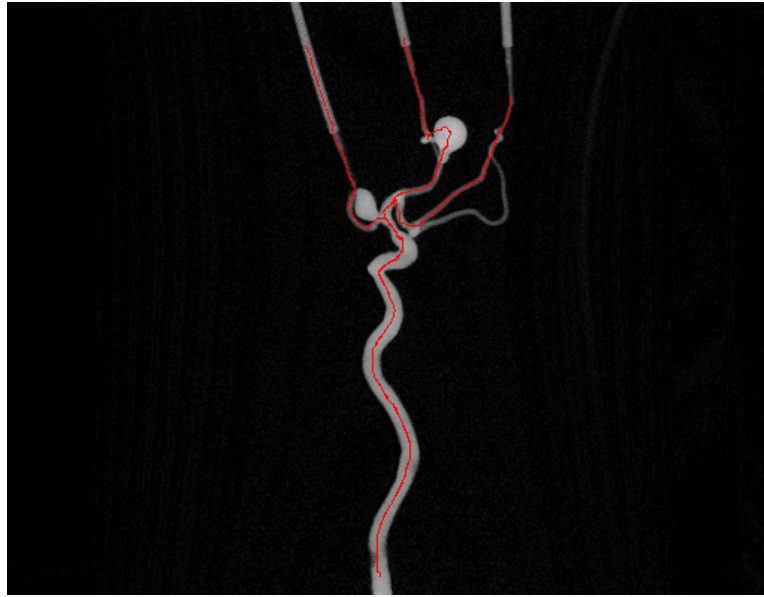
Reconstructed centreline back-projected onto the x-ray image. This image shows two examples of how the centreline could be extracted in the case of a kissing vessel. The centreline in the aneurysm is not well defined (Waechter et al., 2008c).
